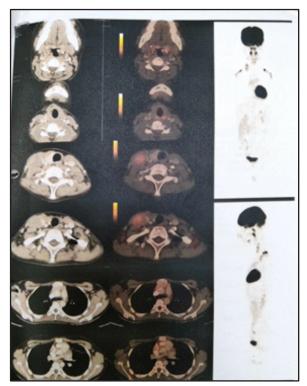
PET CT Images of patient
